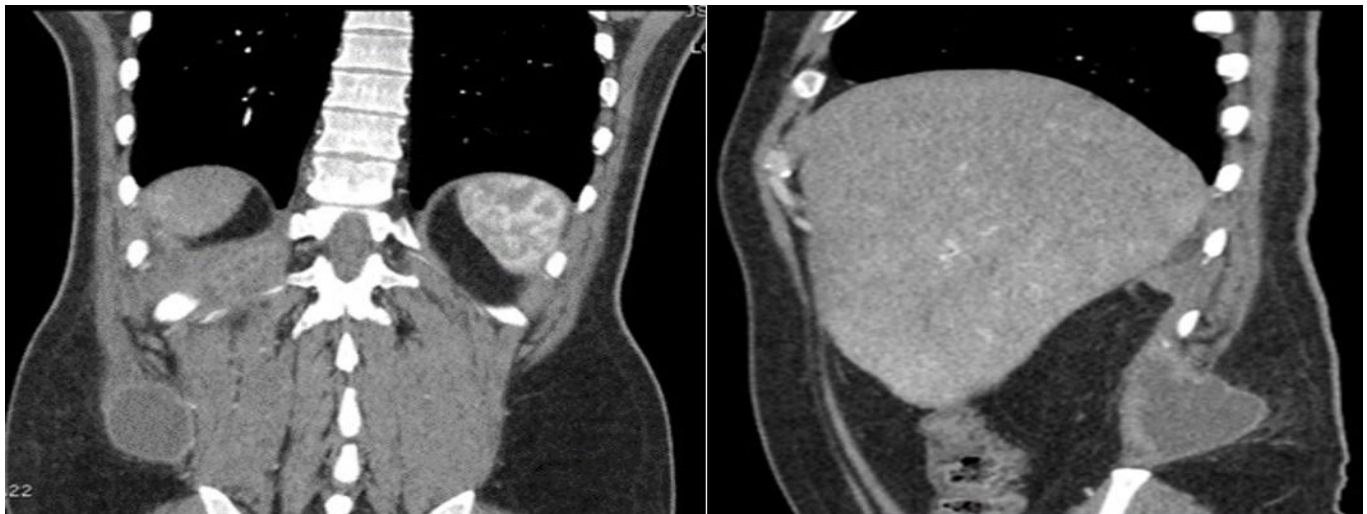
The dynamic liver computed tomography revealed that there was a psoas abscess
